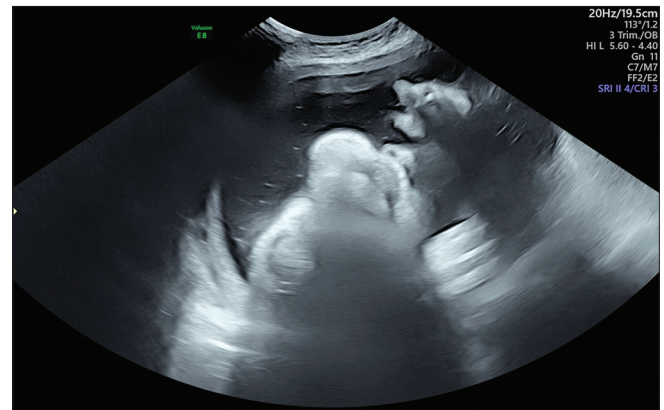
Mid-trimester ultrasound: integrity of the upper lip excluding cleft lip
